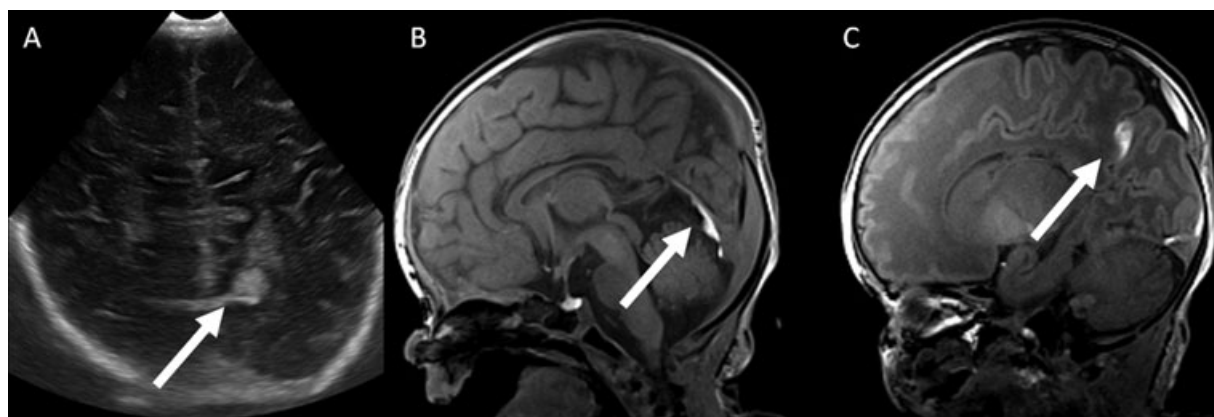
Coronal head ultrasound (A) shows a birth related focal, hyperechogenic left occipito-parietal subarachnoid hemorrhage (arrow) and an adjacent cortical contusion in a several days old neonate. Sagittal T1-weighted MRI shows a small T1-hyperintense infratentorial subdural hematoma (B, arrow) that follows the contour of the tentorium as well as the focal subarachnoid hemorrhage along the parieto-occipital sulcus (C, arrow) next to the cortical contusion. In addition, a small T1-hyperintense epidural hematoma is seen along the supratentorial parieto-occipital bone.
